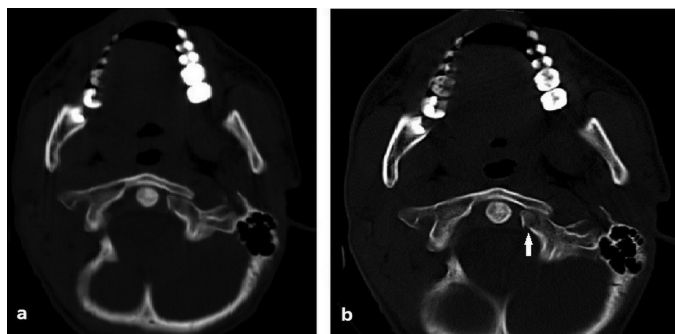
Cranial (a) and maxillofacial (b) axial CT images from skull base. A fracture line is present on the left occipital condyle
